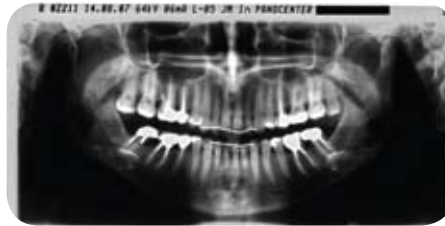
Panoramic radiograph at the end of treatment showing parallel inclination of the lower anterior incisors and augmentation of the bone surrounding the root surface.
